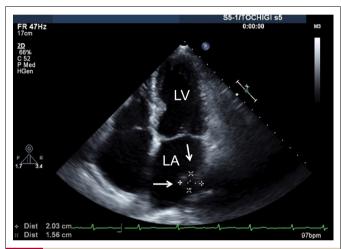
After 5 days of rivaroxaban 10 mg/day treatment, transthoracic echocardiography showed that the thrombus shrunk to $20.3 \text{ mm} \times 15.6 \text{ mm}$ (arrows). LA, left atrium; LV, left ventricle.
